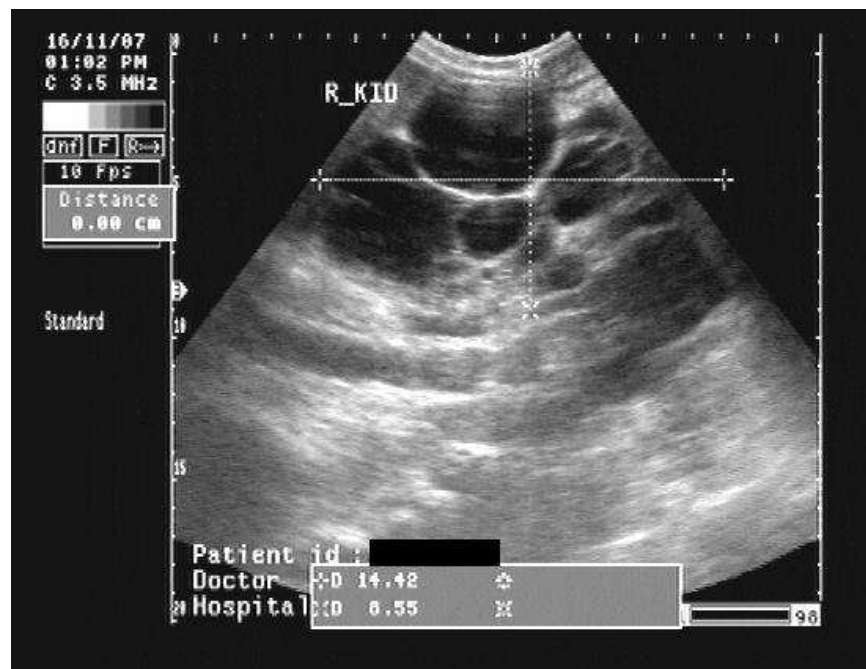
A sample B-mode ultrasound image
